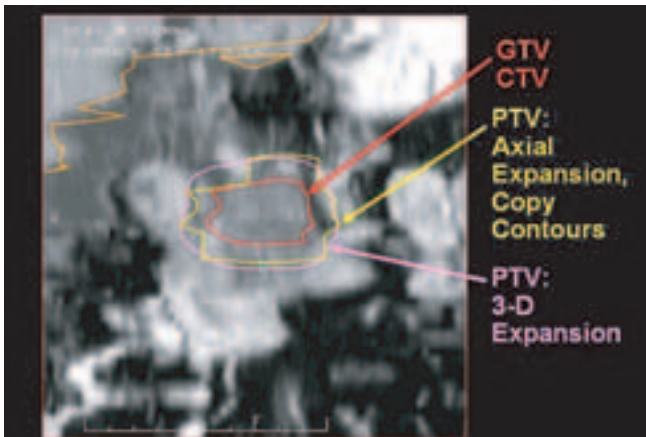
Comparison of target volume (PTV) expansion methods on a coronal CT reconstruction of the pancreas. The light line shows 2-D expansion by expanding contours in 2-D and copying contours at the upper and lower ends of the target. The light grey line shows a fully 3-D expansion of the PTV.
